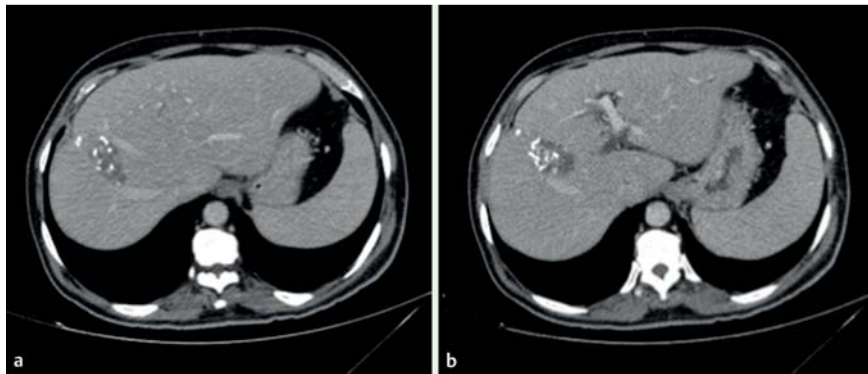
a, b Biliary duct dilatation seen at abdominal computed tomography (CT), in a 49-year-old man presenting with obstructive jaundice and abdominal pain.
